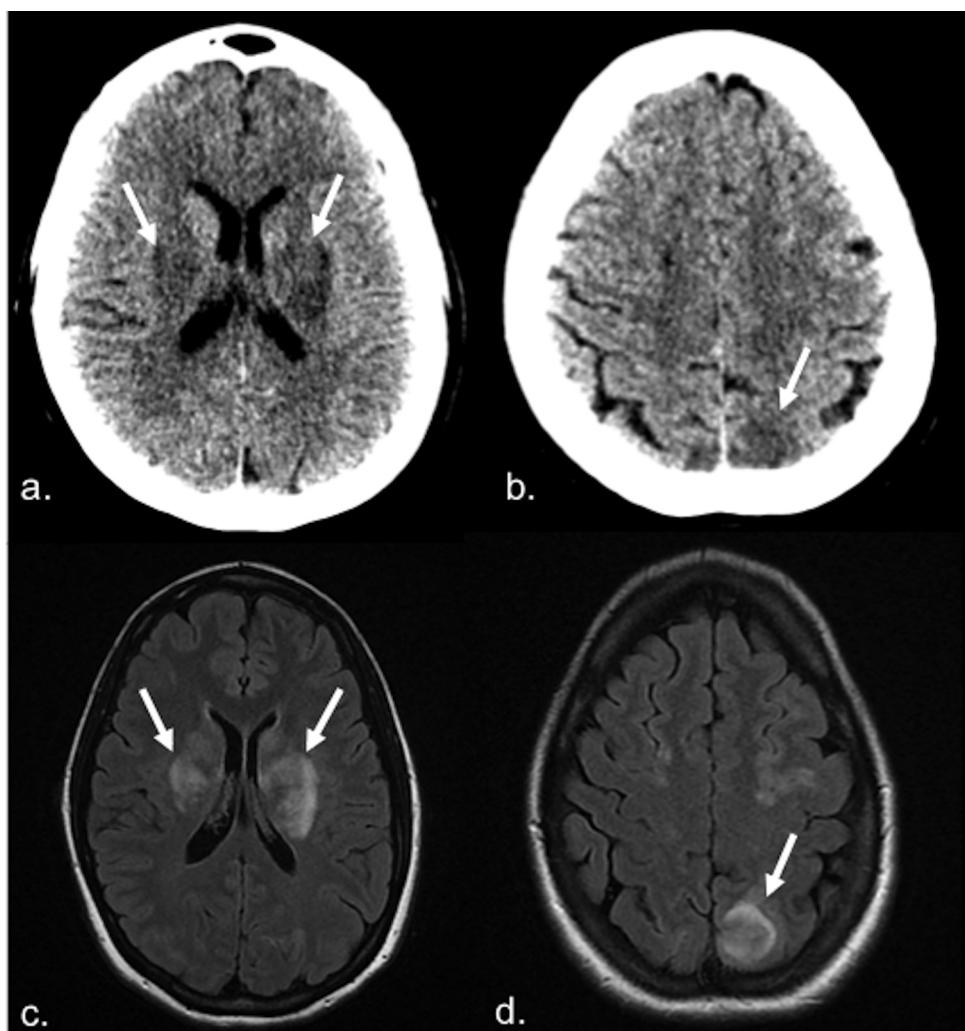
Posterior reversible encephalopathy syndrome (PRES) in a 37-year-old puerperal woman with headache. CT (a and b) shows hypodense areas in the basal and posterior parietal cortical ganglia (arrows). MRI FLAIR images (c and d) correspond to hyperintense areas (arrows), which presented no restricted diffusion (no image shown).
